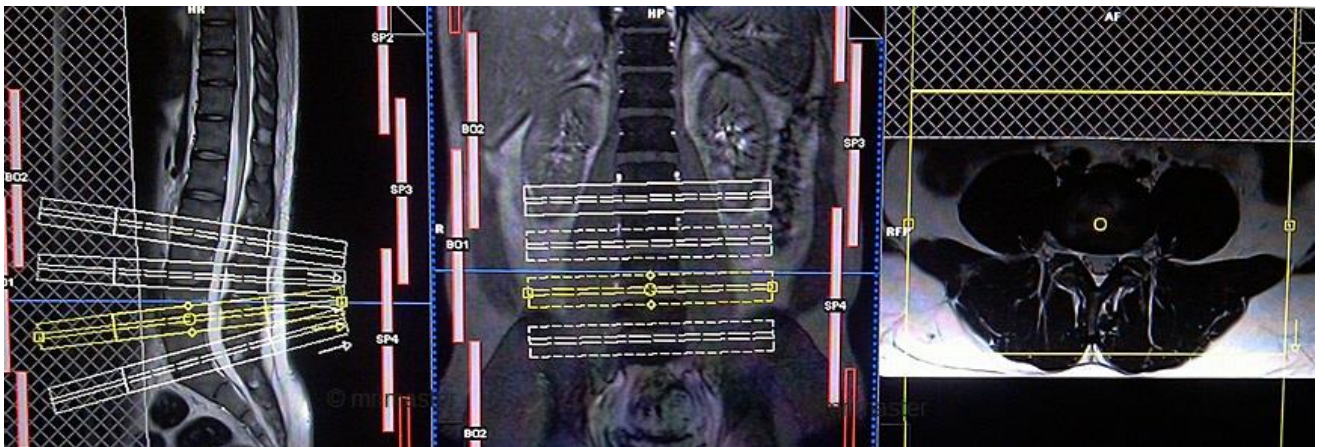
Planning and protocol axial MRI scan for lumbar spine
